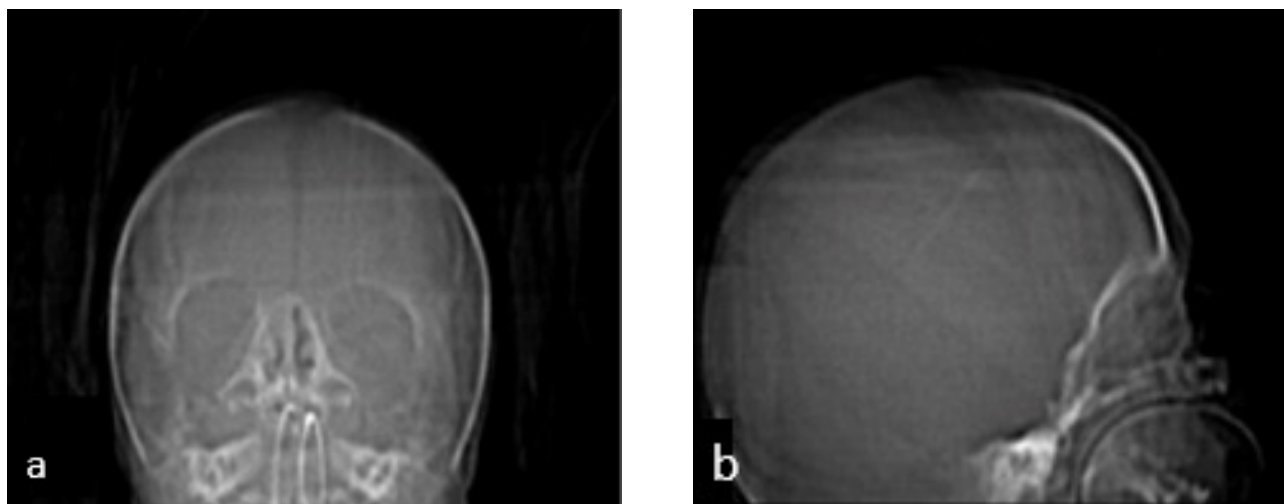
A CT Maxillofacial demonstrated a constellation of findings consistent with TCS including non-visualization of the vomer, soft tissue opacification of the bilateral choana consistent with choanal atresia, micrognathia, irregular/hypoplastic zygomatic arches, aplasia of the external auditory canals, and hypoplasia of the middle ear canals with absent middle ear ossicles, hypoplastic mastoid air cells, unremarkable soft tissues of the face and microtia (fig.2 a.b.)
